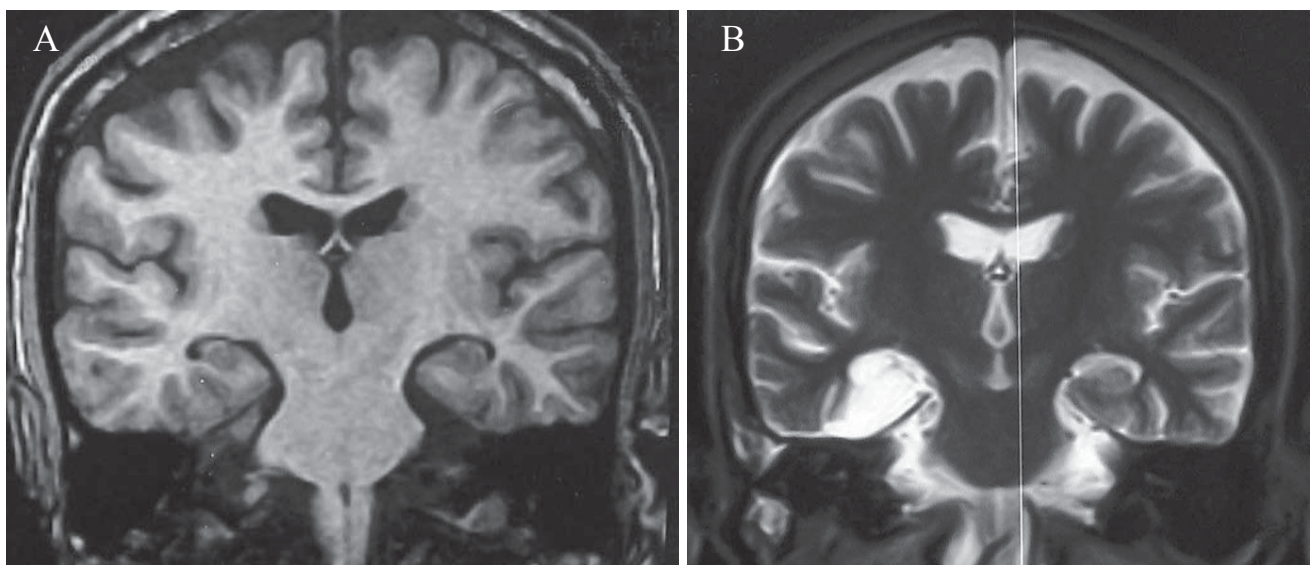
A: Preoperative MRI, TIWI of patient 3 showing right hippocampal sclerosis, B: postoperative MRI, T2WI showing the extent of surgical resection in SAH.
